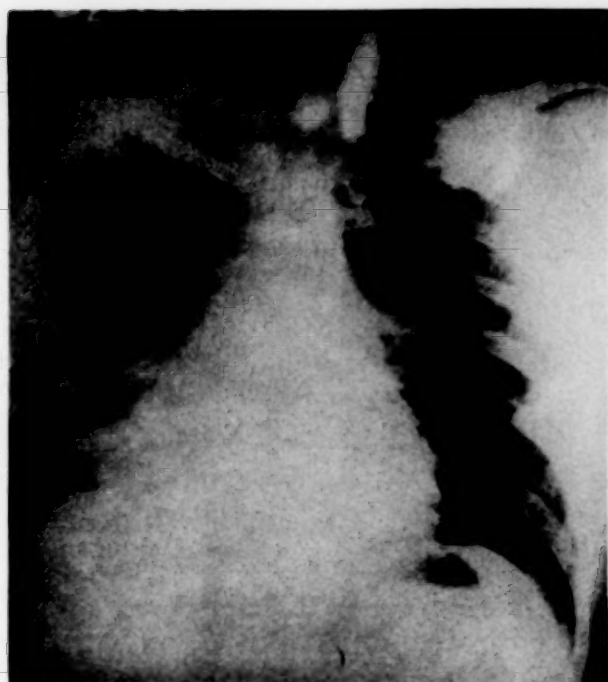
X-ray taken ten days prior to onset of acute symptoms, Case III.
